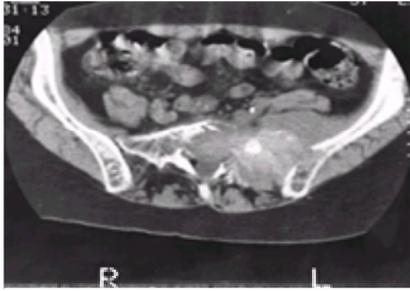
Computed tomography scan at the S1 level in a man with low back pain and pain radiating down the posterior aspect of the left leg. The scan shows a large mass invading the left sacrum with extension to the pelvic sidewall. L, left; R, right.
